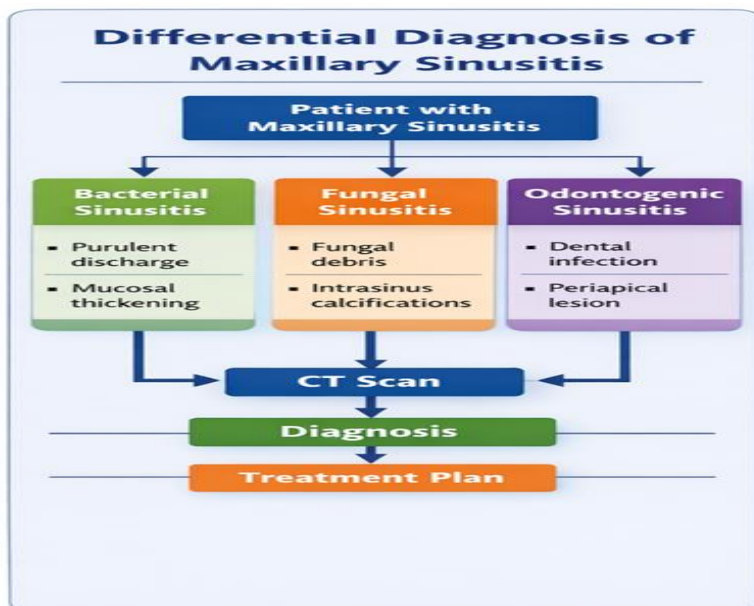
A comprehensive CT-based diagnostic approach for differentiating maxillary sinusitis from other pathologies
